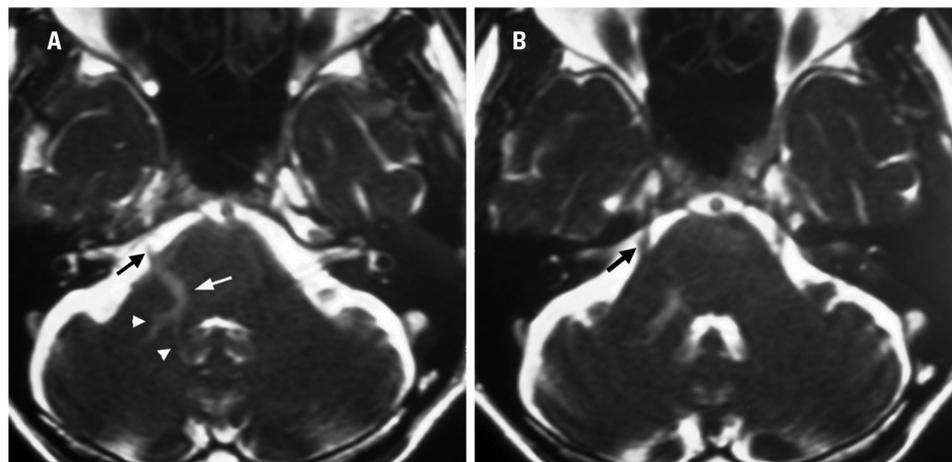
Sequential axial 3D CISS (three-dimensional constructive interference in steady state) MRI (1 mm width) reveals a large right transparenchymal vein (white arrow) and caput medusae (white arrow heads) [A] as well as the course of the trigeminal nerve (black arrow) and its relationships to the developmental venous anomaly (DVA) within the brachium pontis [A and B].
